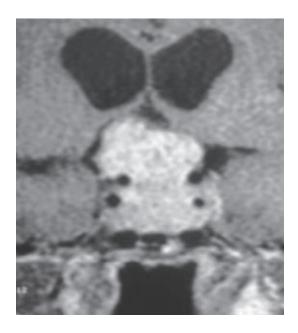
MRI of the brain coronal section shows giant macroadenoma compressing the third ventricle that produces obstructive hydrocephalus.
